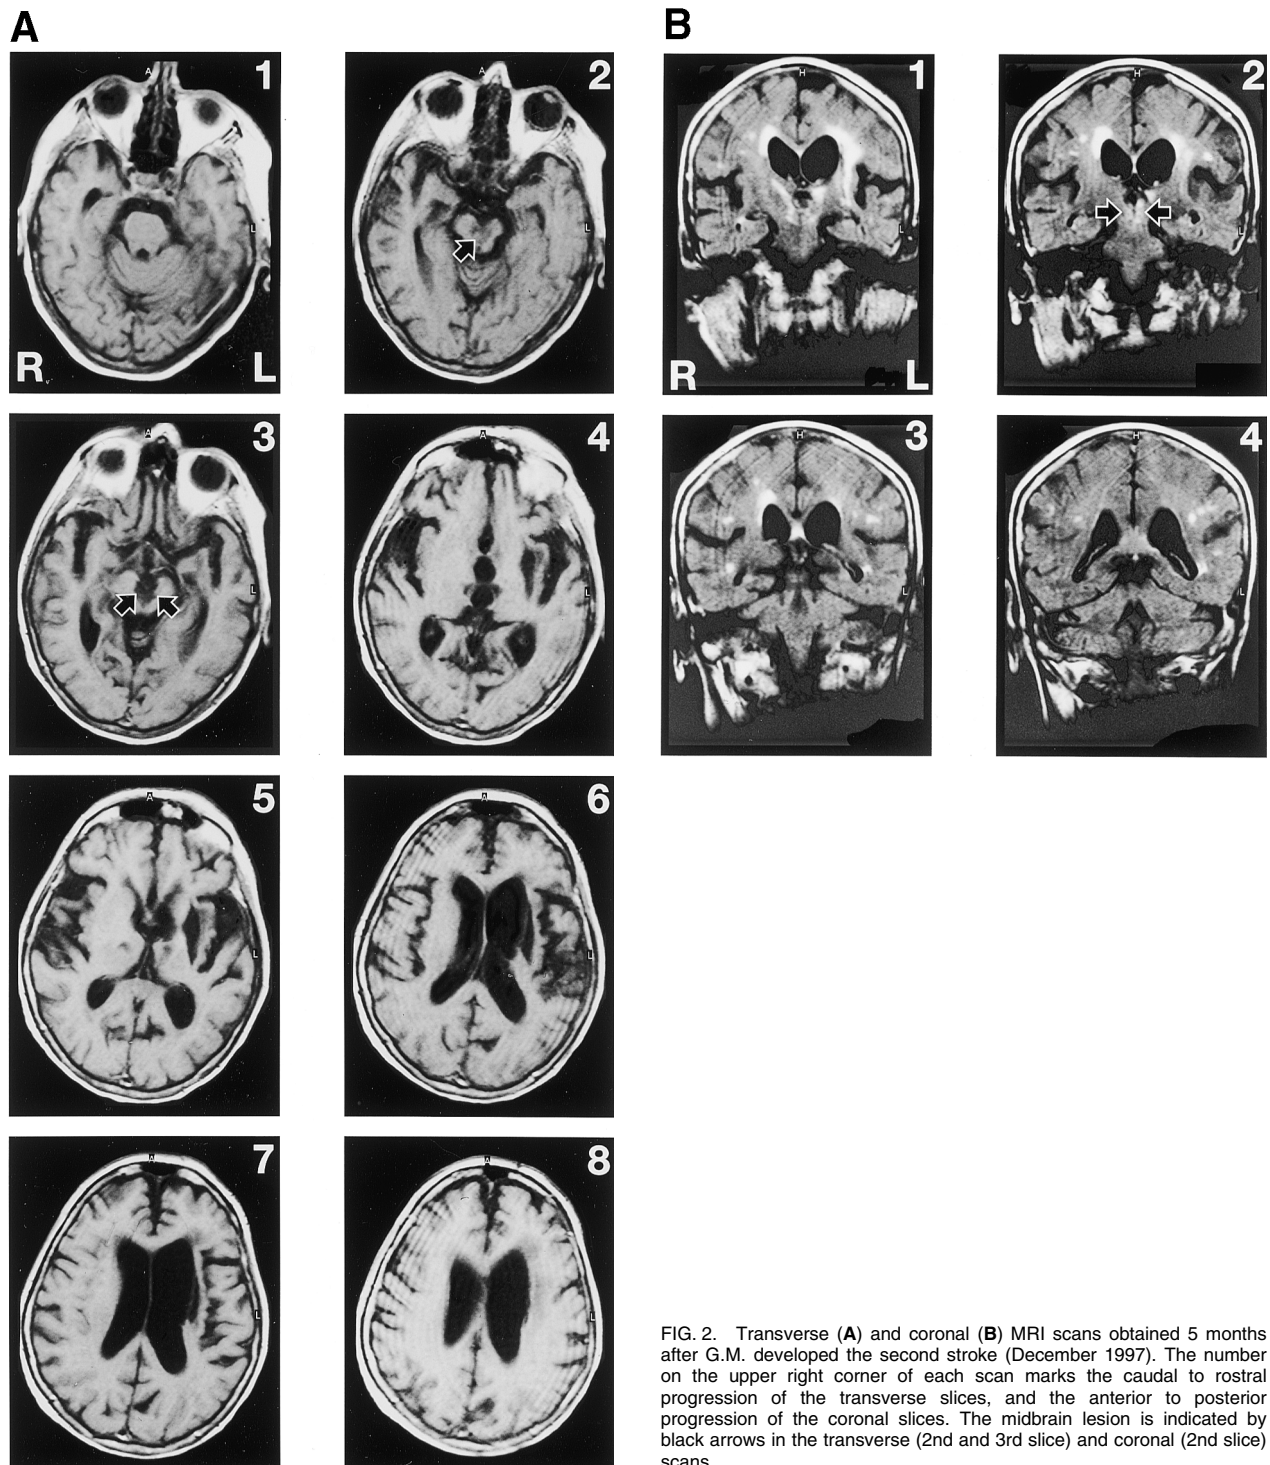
Transverse (A) and coronal (B) MRI scans obtained 5 months after G.M. developed the second stroke (December 1997). The number on the upper right corner of each scan marks the caudal to rostral progression of the transverse slices, and the anterior to posterior progression of the coronal slices. The midbrain lesion is indicated by black arrows in the transverse (2nd and 3rd slice) and coronal (2nd slice) scans.
